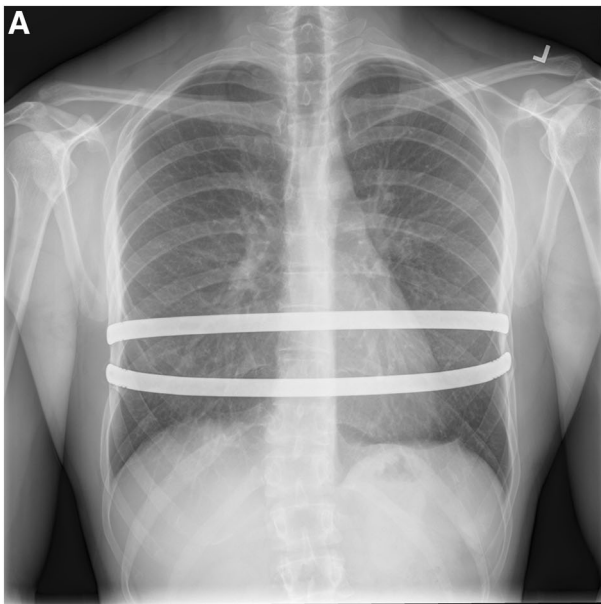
a Antero-posterior chest X-ray with *two bars*. b Lateral chest x-ray
